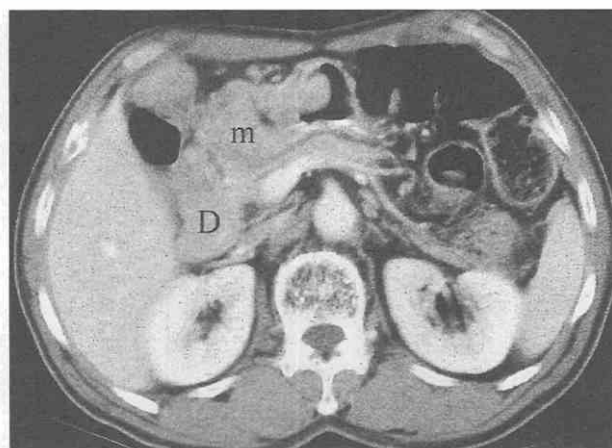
Intramural duodenal spread from gastric cancer. CT scan shows a large polypoid mass (m) in the stomach extending into the second portion of the duodenum (D).
